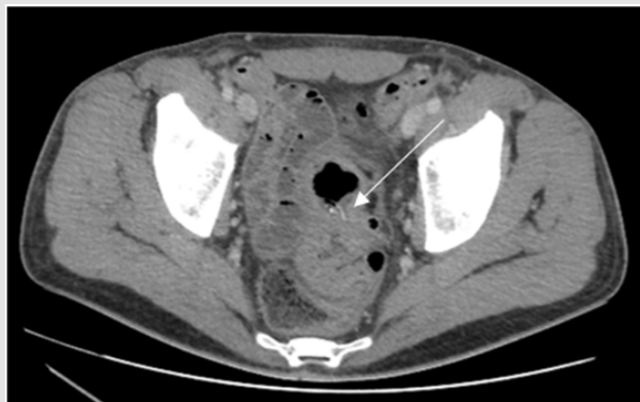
Contrast-enhanced CT (at 48h). Sigmoid diffuse thickening associated with sigmoid diverticulosis. Lineal filiform foreign body probably emplaced in a diverticulum, with bone density (marked by the arrow).
